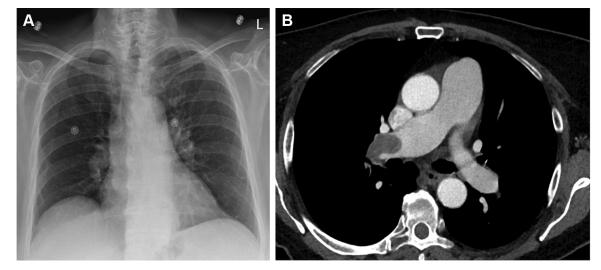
A, Posterior-anterior chest radiograph in a 76-y-old woman with shortness of breath and chest pain, demonstrating asymmetrical lucency in the right lung consistent with Westermark sign and dilated right inferior pulmonary artery (Palla sign). B, CT scans (axial view) showing large right pulmonary embolism.
